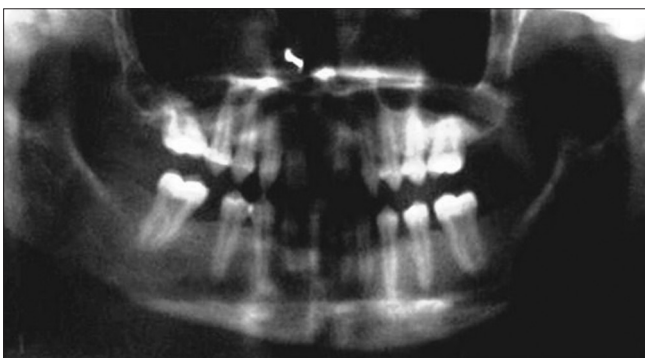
Panoramic radiograph showing missing 12, 17, 22, 27, 37, 42, 47. Taurodontism with 36 and 46
